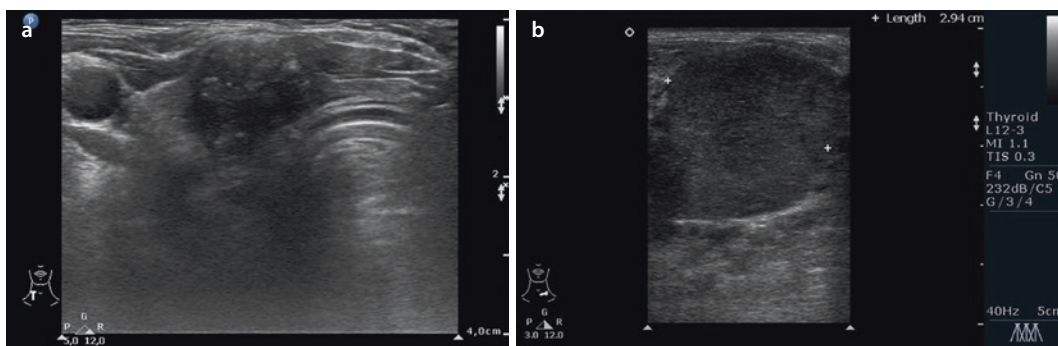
Ultrasonographic images of a right sided MTC a and a pathological hypoechoic lymph node on the left side b
